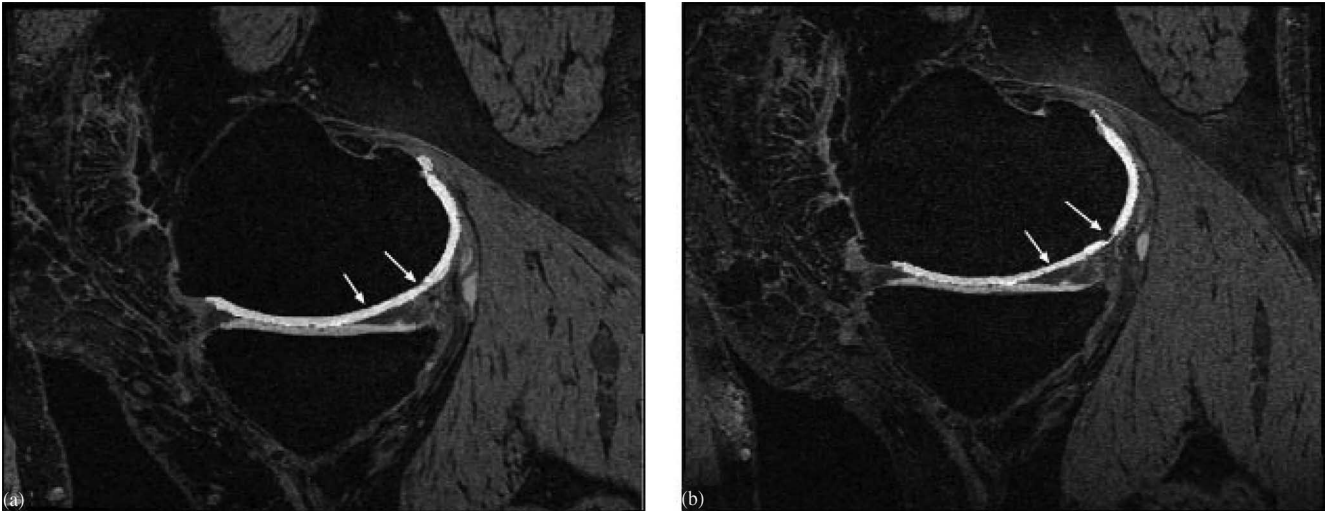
MR images of an osteoarthritic individual showing medial femur loss of cartilage thickness near the posterior meniscus region between (a) the baseline and (b) 12-month follow-up. Arrows indicate the cartilage loss.
